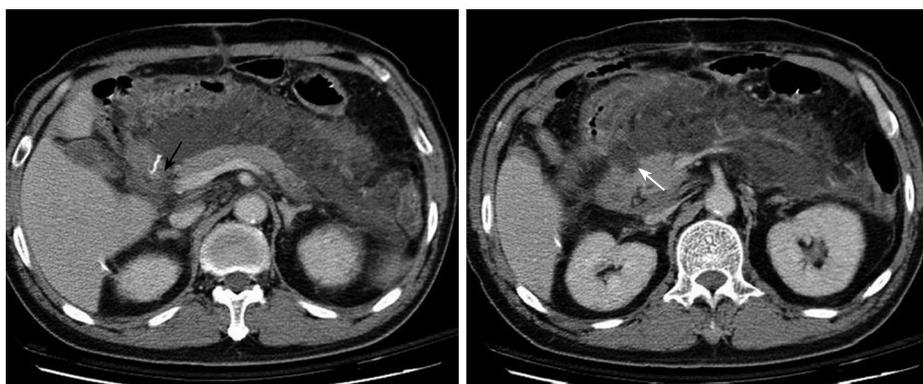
Abdominal CT 8 d after the first operation demonstrates massive fluid accumulation in the peripancreatic area and the lesser sac. The homogenous fluid extends to the retroperitoneal space. The status of the duodenal stump (black arrow) cannot be clearly assessed. The pancreas is well enhanced and enlarged, and the head shows an uneven and infiltrative margin (white arrow).
